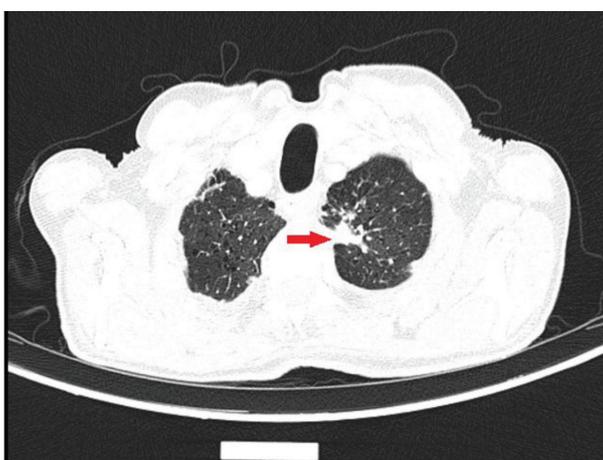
IV Contrast CT study showing Irregular lesion 2.4*1.4cm with calcification in periphery in Left Lung Apex.
